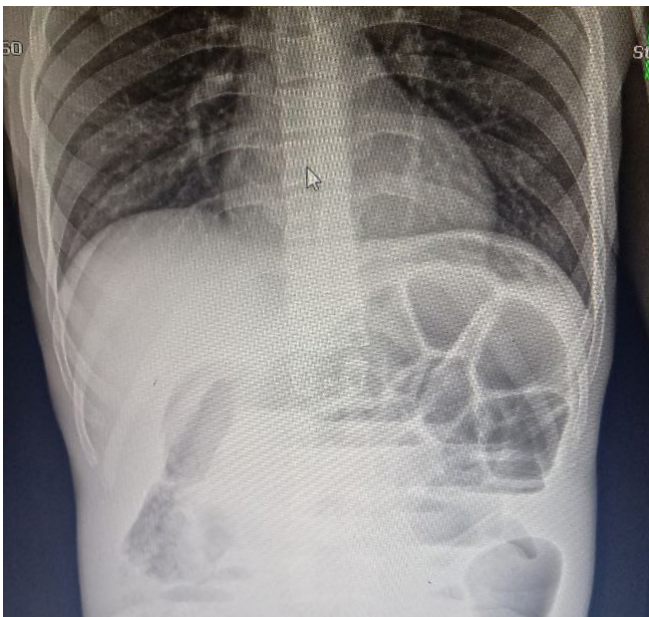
Abdominal X-ray showing dilated small and large bowel with significant multiple air-fluid levels (Credit: Dr Derilo Legesse)
